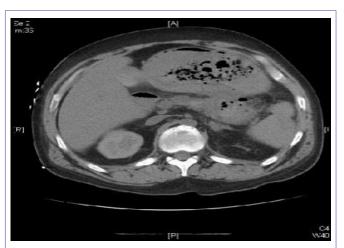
CT abdomen: Note chronic pancreatic atrophy and pseudocyst abating stomach.
